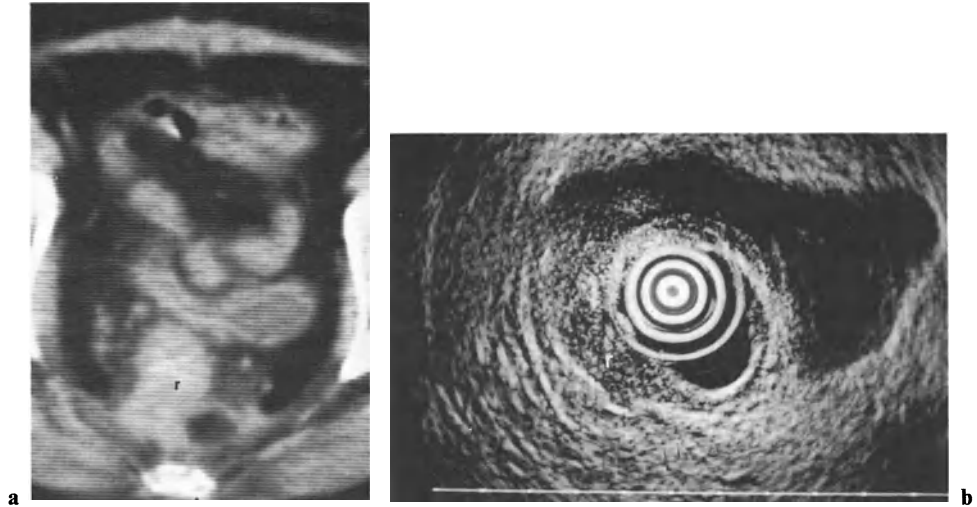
a, b. CT and RS: local recurrence (*r*) after hysterectomy and ovariectomy for carcinoma of ovaries with extension into rectum
